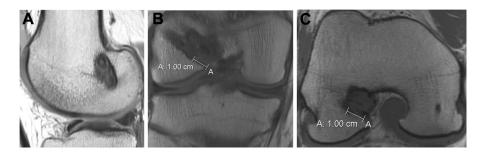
Femoral tunnel communication seen on (A) sagittal proton-density (PD)-weighted MRI of right knee. Both grafts are seen in a common aperture at the lateral femoral condyle.⁵ (B) Coronal T1-weighted MRI of right knee. No bony bridge between the tunnels is visible 1 cm from the articular surface.⁵ (C) Oblique axial T1-weighted MRI of right knee. No bony bridge between the tunnels is visible 1 cm from the articular surface.⁵
